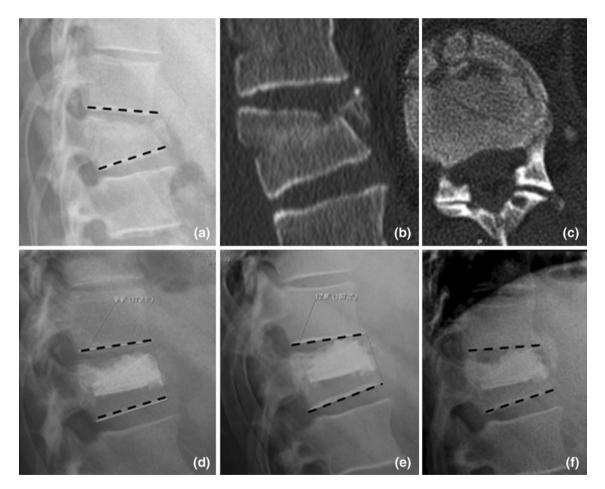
Incomplete superior burst fracture of T12 (45-year-old male patient) treated with vertebral body stent and polymethylmethacrylate bone cement (PMMA). a Standing preoperative radiograph. b, c Preoperative computed tomography (CT) shows persistent kyphosis, destruction of the anterior part of the endplate, intact posterior wall and pedicles. d First postoperative standing radiograph with reduction of the segmental kyphotic deformity from  $30^{\circ}$  to  $10^{\circ}$ . e Loss of intervertebral disc height at 2 months follow up and increase of segmental kyphosis to  $13^{\circ}$ . f 'Spontaneous' fusion at 6 months follow up between T11 and T12, with segmental kyphosis of  $15^{\circ}$
